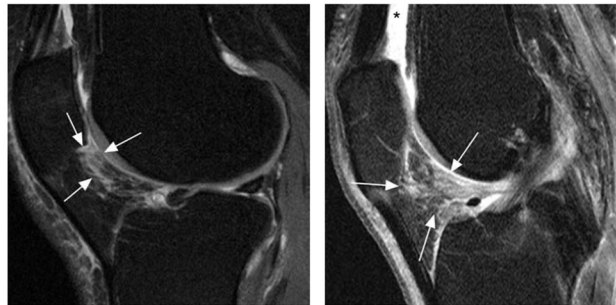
Hoffa-synovitis. A. Sagittal intermediate-weighted fat suppressed image shows infrapatellar areas of hyperintensity within Hoffa's fat pad representing a surrogate of synovitis on non enhanced MRI. In this case grade 2 Hoffa-synovitis is shown (arrows). B. Another knee exhibits marked signal alterations within Hoffa's fat pad representing grade 3 Hoffa-synovitis (arrows). Note effusion-synovitis in addition (asterisk).
